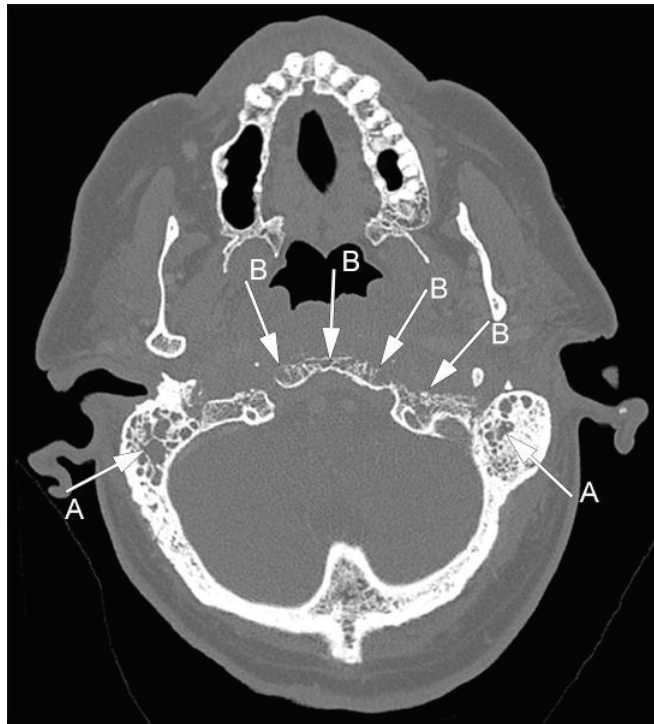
Axial computed tomography image on bone window setting at the same level as Figure 1, note bilateral opacified mastoid air cell complexes (A). There is diffuse erosion/ destruction of the skull bone adjacent to the mass involving the left petrous temporal bone and clivus (B).
